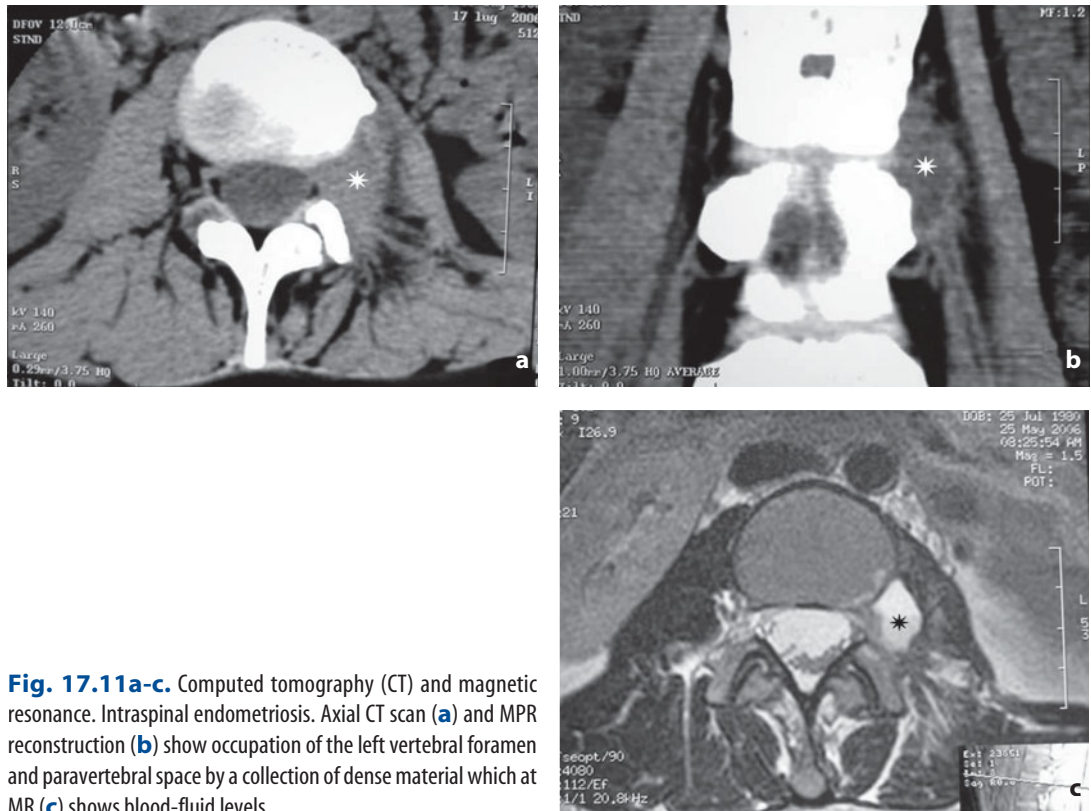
Computed tomography (CT) and magnetic resonance. Intraspinal endometriosis. Axial CT scan (a) and MPR reconstruction (b) show occupation of the left vertebral foramen and paravertebral space by a collection of dense material which at MR (c) shows blood-fluid levels
